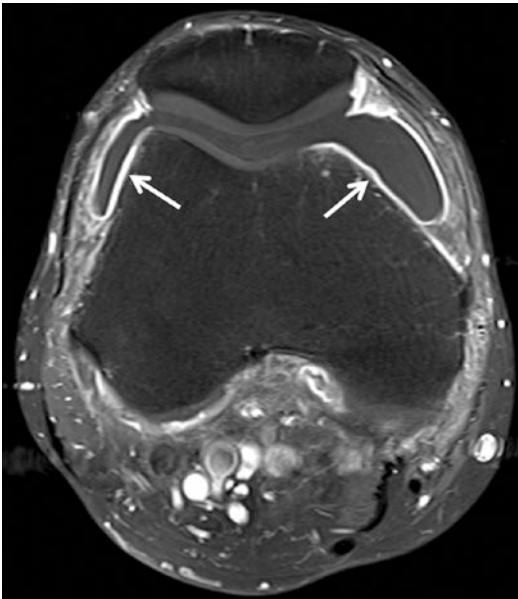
Fat-suppressed Gd-enhanced T1-weighted axial MR image shows enhanced synovium (arrows) distinguished from non-enhanced effusion
